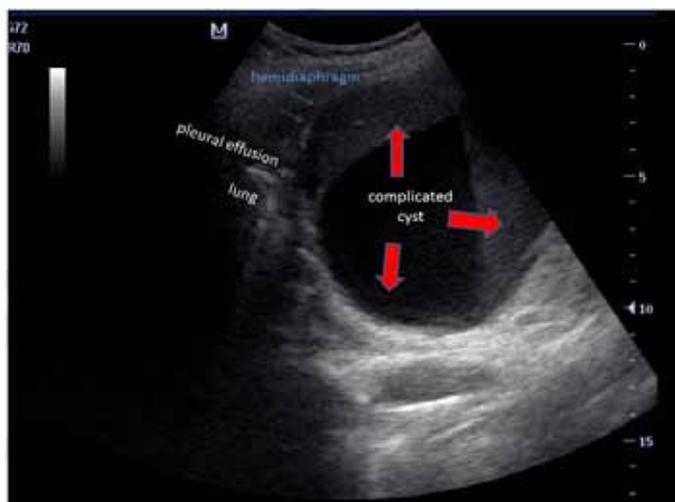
Thoracic ultrasound showing a big sub diaphragmatic cystic formation pressing against hemidiaphragm with mixed content, both a cystic area and a solid component (arrows). The splenic border was displaced by cystic formation effect. It showed also a small pleural effusion in left costophrenic angle.
